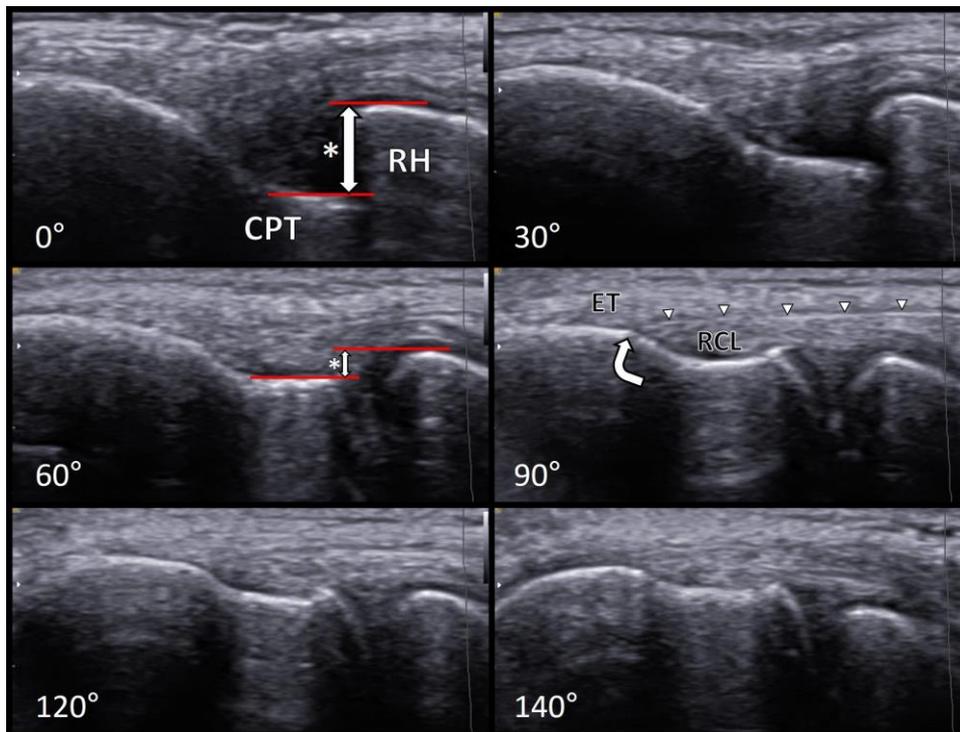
Ultrasonographic images of the radial collateral ligament (RCL) at 6 elbow flexion angles. Depth interval (asterisk) was defined as the depth of the capitellum (CPT) subtracted by the depth of radial head (RH) on the ultrasonography (US). Hyperechogenic line (arrow head) and a superior tubercle (curved arrow) are shown on the US image of a 90° flexed elbow, separating RCL from extensor tendon (ET).
